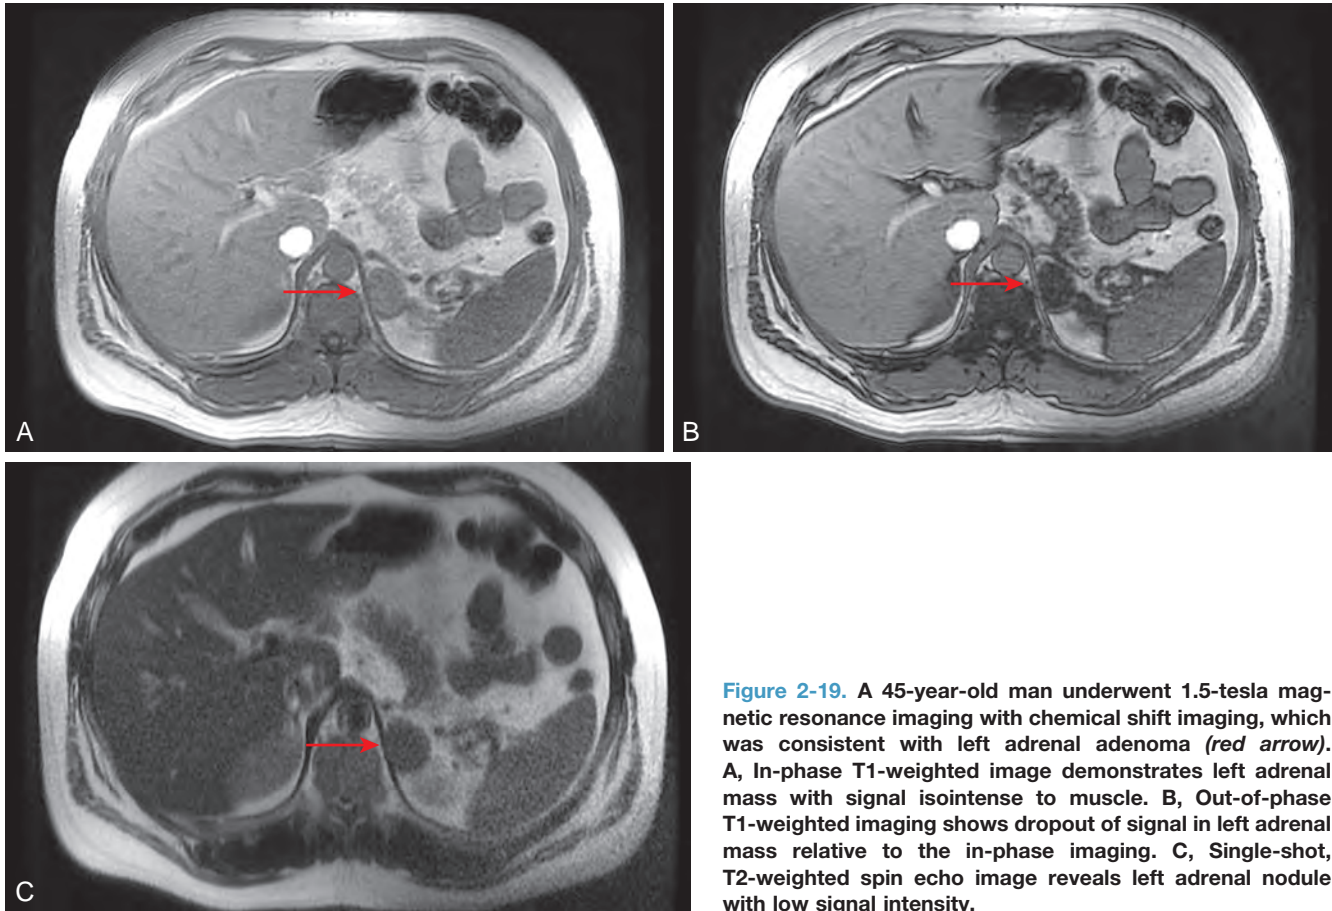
A 45-year-old man underwent 1.5-tesla magnetic resonance imaging with chemical shift imaging, which was consistent with left adrenal adenoma (red arrow). A, In-phase T1-weighted image demonstrates left adrenal mass with signal isointense to muscle. B, Out-of-phase T1-weighted imaging shows dropout of signal in left adrenal mass relative to the in-phase imaging. C, Single-shot, T2-weighted spin echo image reveals left adrenal nodule with low signal intensity.
